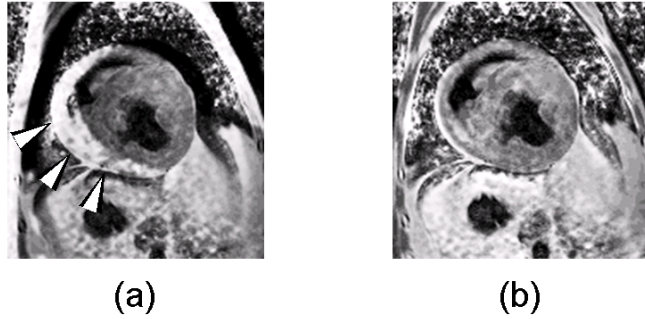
T2-weighted image divided by deformed PD-weighted image in (b) shows mis-registered myocardial intensity artifacts (arrows in a) is suppressed after the image warping.
